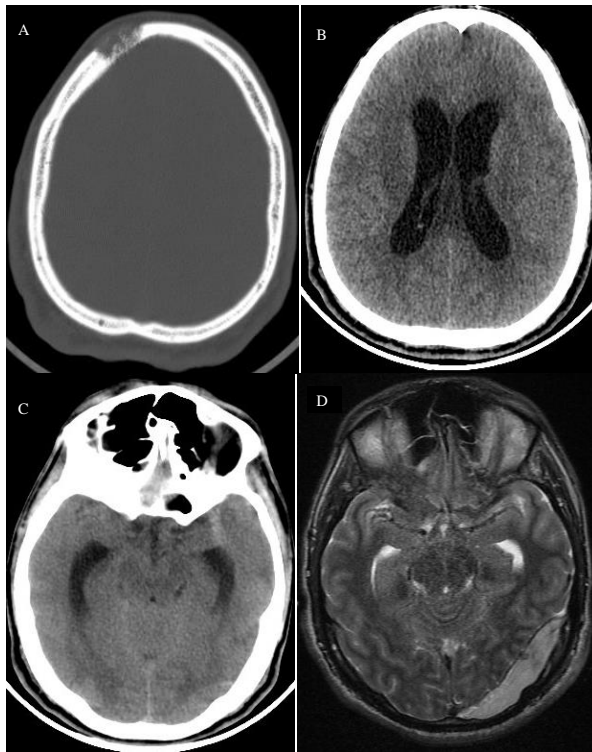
(A) Brain CT scan showed osteolytic lesions on the right side of the frontal bone, (B) Brain imagery had demonstrated ventricular hydrocephalus; (C) left temporo-parietal extradural hematoma; (D) brain imagery after EVS showed an increase in the size of the extra-dural hematoma.
